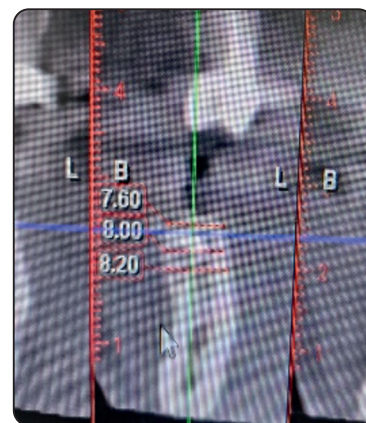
Postoperative radiographic assessment showing the bone gain at both levels from the alveolar ridge crest
